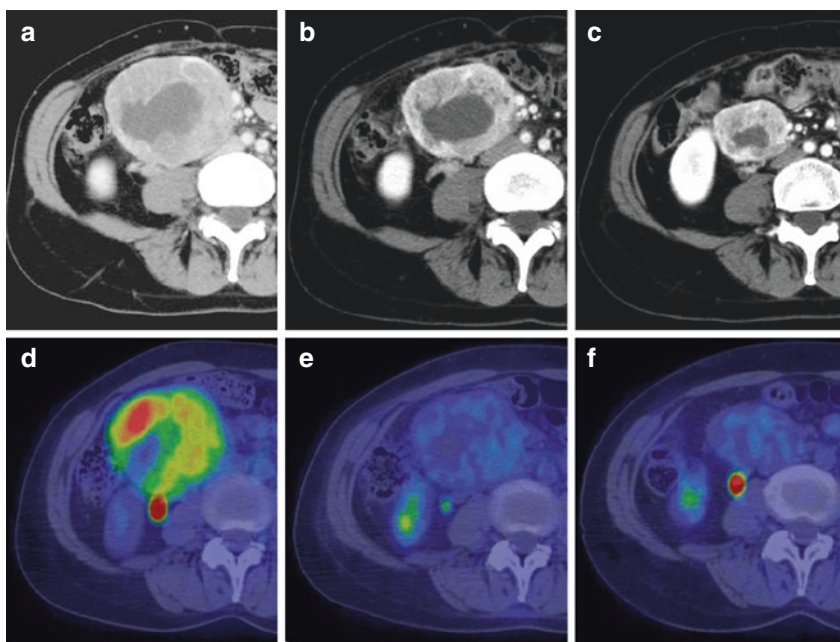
A 40s' female with primary gastrointestinal stromal tumors of duodenum. (a) A pretreatment contrast-enhanced CT image depicts a lesion with heterogeneous density as large as 90 mm. (b) A contrast-enhanced CT image obtained at 2 weeks after the initiation of the treatment using imatinib mesylate shows a mildly shrunken tumor. (c) A contrast-enhanced CT image obtained at 8 months later shows a shrunken tumor as small as 50 mm. (d) A pretreatment FDG/PET fusion image shows strong activity in the tumor (SUVmax = 8.13). (e) An FDG/PET fusion image obtained at 2 weeks later shows dramatically decreased activity in the tumor (SUVmax = 2.99). (f) An FDG/PET fusion image obtained at 8 months later indicates low activity in the tumor (SUVmax = 1.70). These images demonstrate that FDG PET can predict the therapeutic effects earlier than morphological imaging tests
